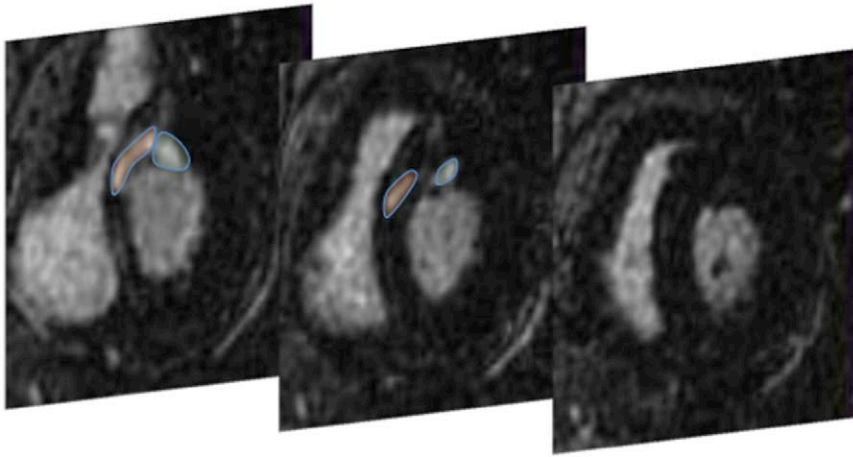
Stack of 3 short-axis views from a delayed-enhanced MRI image (basal, left; apical, right). In light orange, area of intramural delayed enhancement; in light blue, endocardial delayed enhancement secondary to 2 prior failed ablation procedures.
